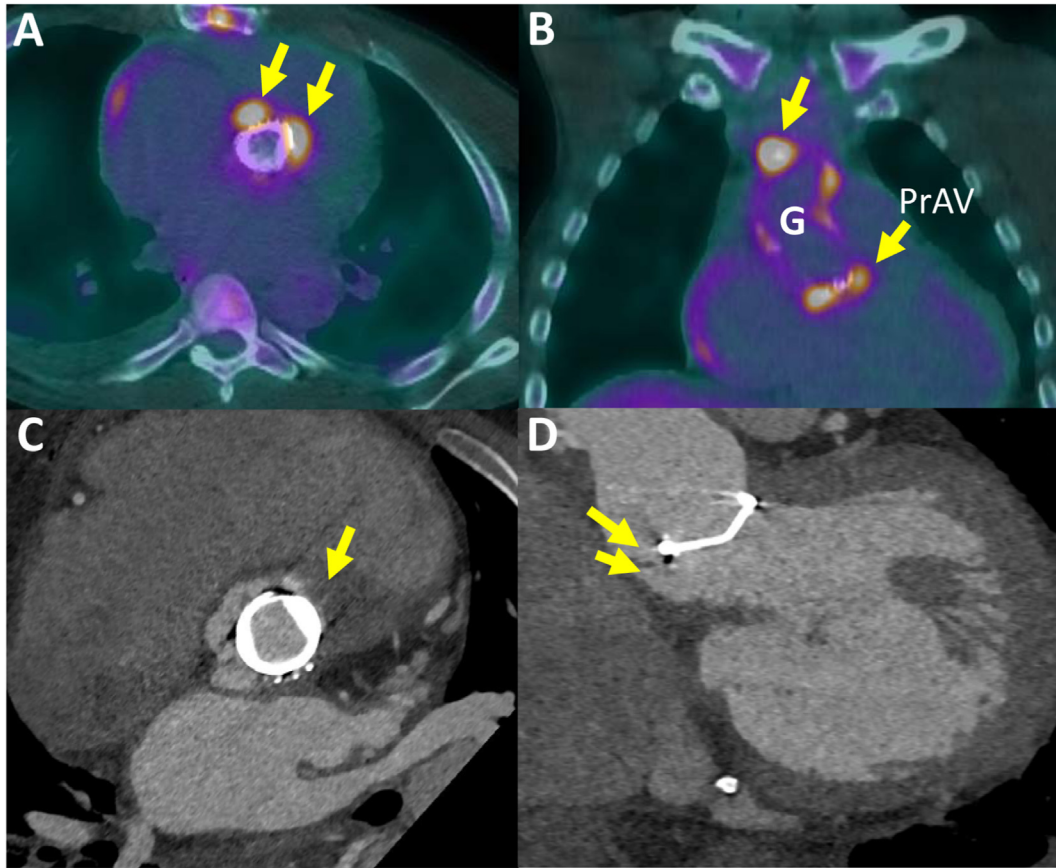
Example of endocarditis affecting a mechanical aortic valve and ascending aortic graft (G), detected on fluorodeoxyglucose (FDG) PET. The patient presented with malaise and dyspnea. Dehiscence of the bileaflet valve and severe AR were detected by TTE. FDG PET performed after prolonged fasting showed intense uptake around the aortic valve in the area of suggested abscess (A, arrows) and, importantly, also in the aortic graft (B, upper arrow). Computed tomographic angiography confirmed the possible abscess anterior to the aortic valve (C, arrow) and dehiscence of the aortic valve prosthesis (PrAV) with a 10-mm PVL (D, arrows).
